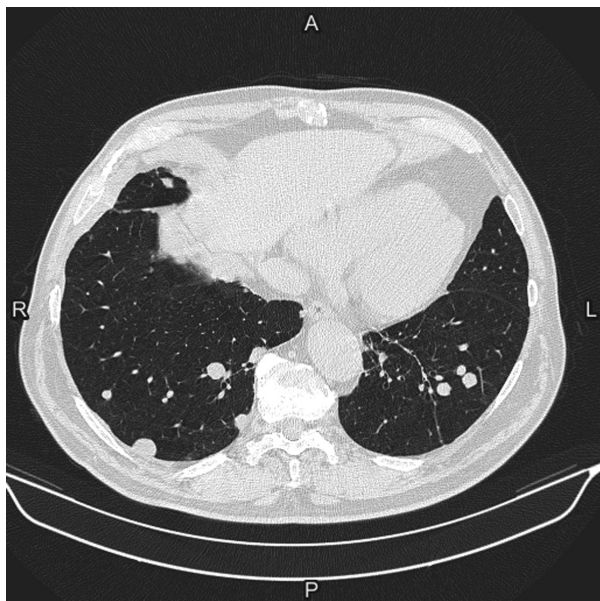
CT scan of the chest in April 2013 showing increased number of pulmonary nodules in comparison to the last check (8 months before)
